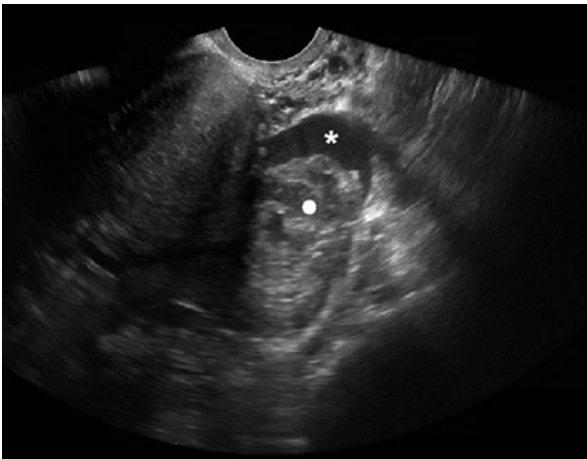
Adnexal complex free fluid. Transvaginal ultrasound showing complex free fluid (\*) around an adnexa (●) in patient with a ruptured tubal ectopic pregnancy
